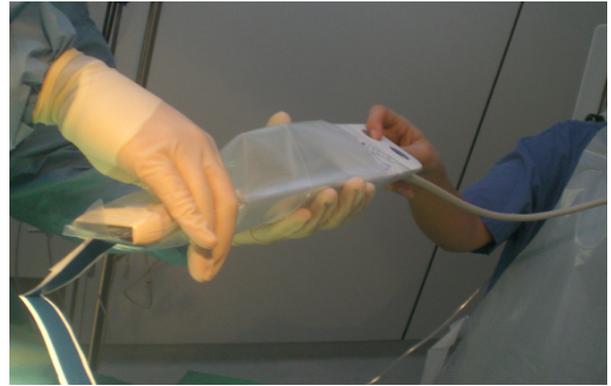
CVC-insertion internal jugular vein using ultrasound: The probe is provided with a sterile cover. The puncture is done under visual control.
